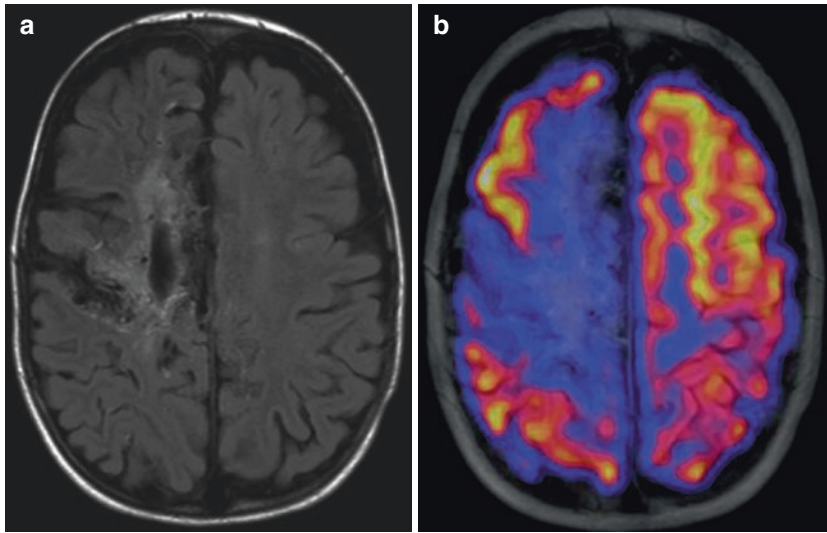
Case of a 5-year-old boy with CPA. T2-weighted FLAIR MRI transaxial slide (a), and fused $[^{18}\text{F}]\text{FDG}$ PET-MRI (b), showing a more extended area of hypometabolism of the right cortex, especially at the frontal cortex compared to the MRI
